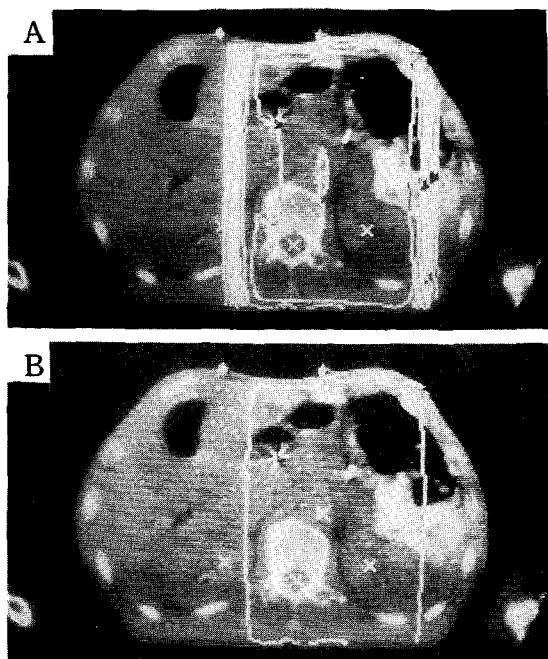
Planning CT (corrected).
